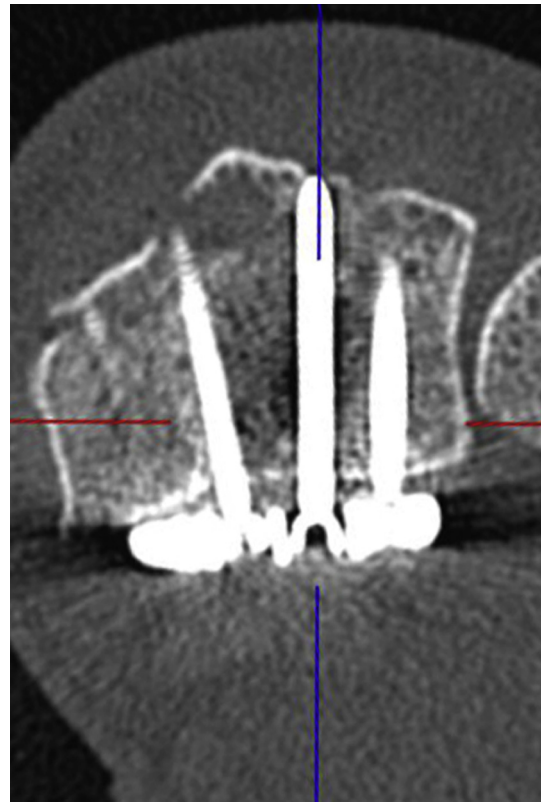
The distances between screw tips and dorsal radial cortex were evaluated on the basis of CT reconstructions parallel to the screws.
